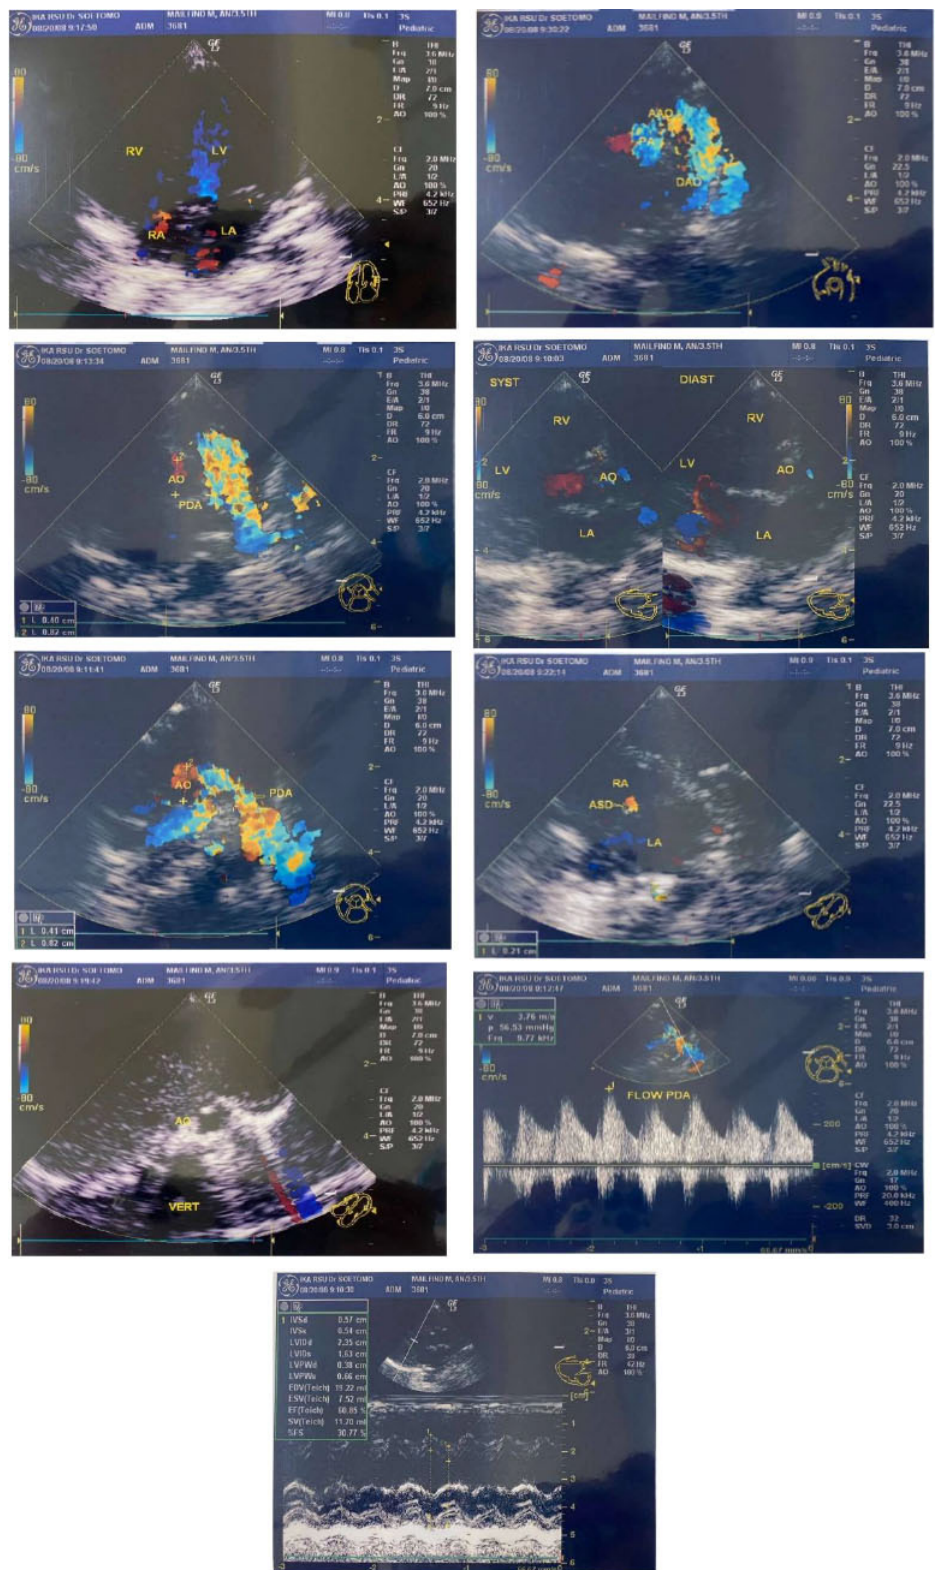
Echocardiography results in 2008 at dr. Soetomo Hospital, Surabaya.
